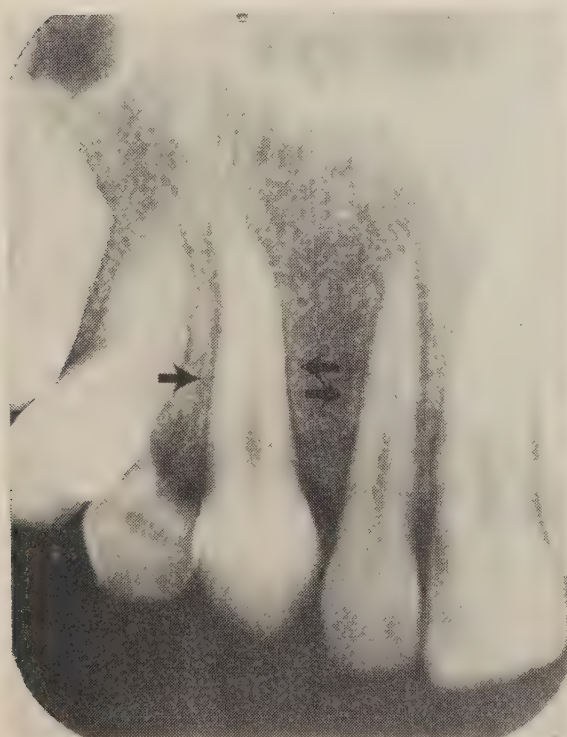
Periapical radiographs of upper jaw after parathyroidectomy. Note regeneration of the lamina dura (arrows).
